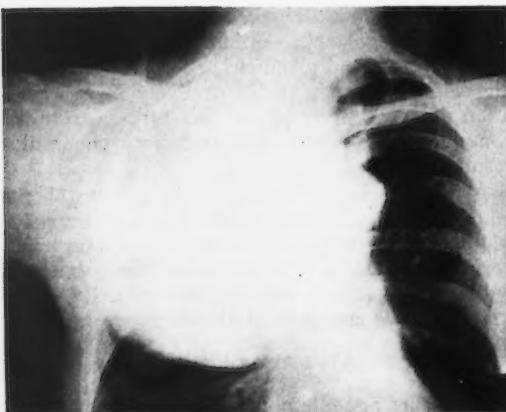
Roentgen-ray graph of a large intrathoracic goiter. Patient in good health.
